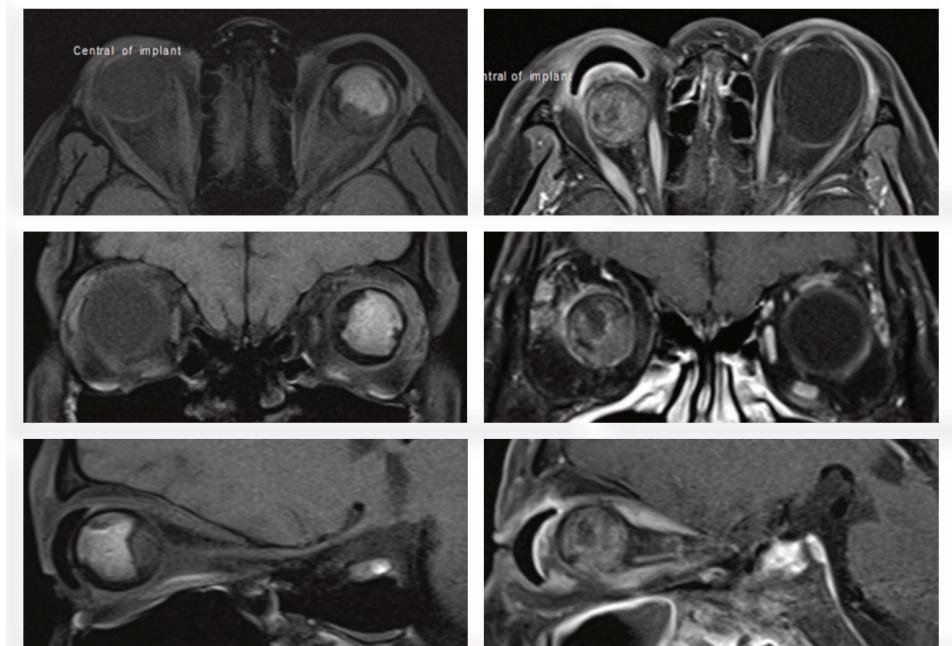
Post contrast T1-weighted 1.5 Tesla MRI in evisceration (left) and enucleation (right) patients. Each patient was tested in axial (top), coronal (middle) and sagittal (bottom) planes. The areas of enhancement were marked by a technician and verified by a neuroradiologist
